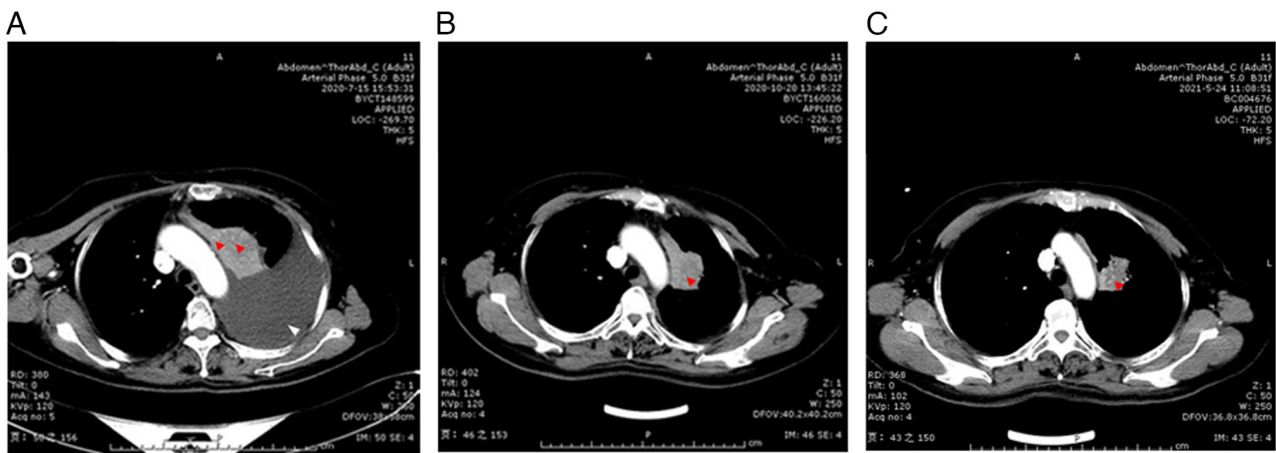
Enhanced chest computed tomography of the patient to assess disease status and progression before and after treatment with intrapleural perfusion hyperthermia-adjuvant chemotherapy. (A) Image captured on August 23, 2020. Red arrows indicate metastatic focus before treatment. High-density arc-shaped shadows indicate the malignant pleural effusion (white arrows). (B and C) Images captured on September 23, 2020 and April 10, 2021, respectively. Red arrows indicate metastatic focus, showing that the tumor size has decreased after treatment and following chemotherapy.
